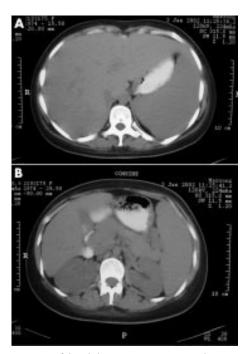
(A) CT of the abdomen 3 January 2002 showing hepatosplenomegaly. (B) CT of the abdomen showing abdominal lymphadenopathy.
